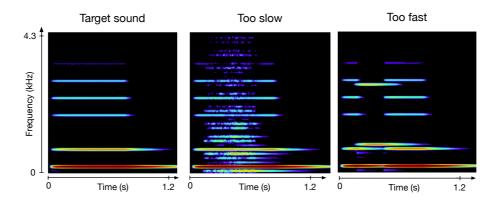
Sonograms of the three example sounds; left: target sound produced if the movement matches exactly the target velocity profile *i.e.* the plain line in Figure 3; middle: sound containing noise produced by a slow movement; right: sound with the higher harmonic produced by a too fast movement.
